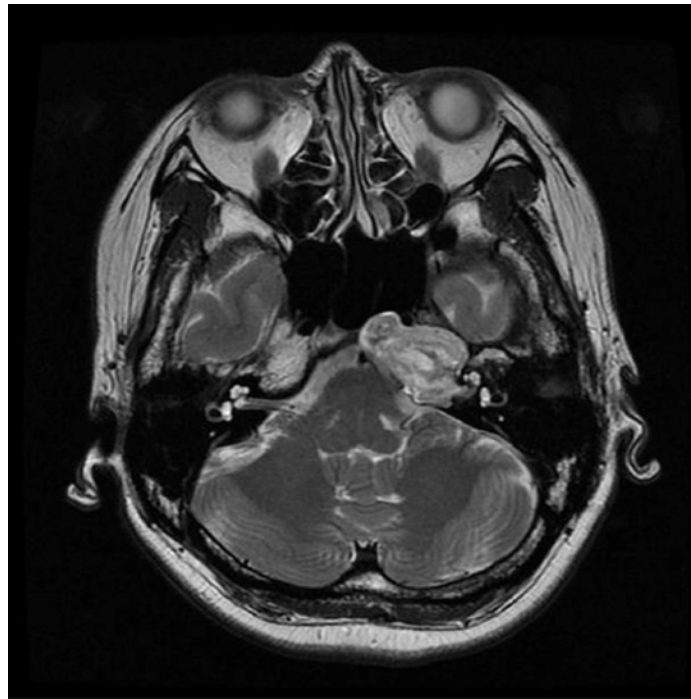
T2-weighted MRI. A huge cholesteatoma existed in the petrous apex, extending to the sphenoid sinus and involving the internal auditory meatus (IAM) and the internal carotid artery (ICA).
